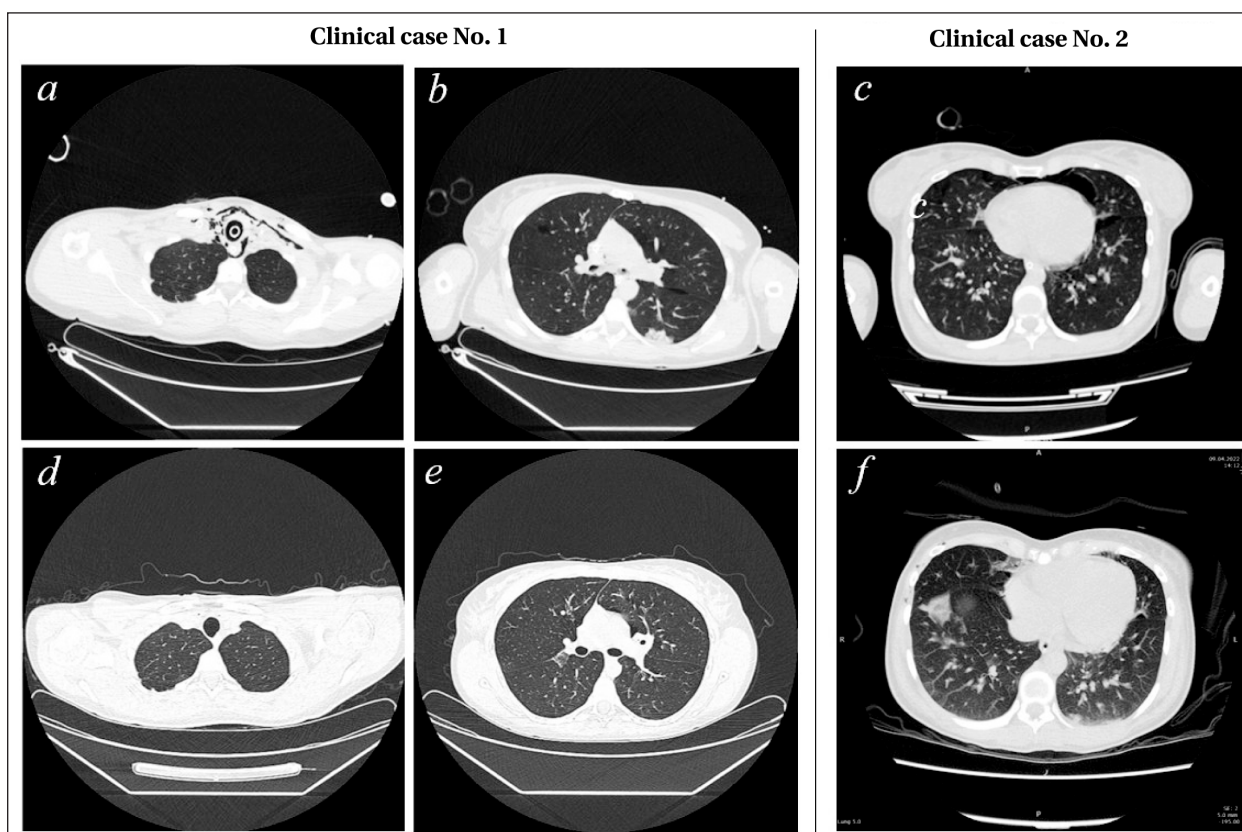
Dynamics of changes in chest CT scans.
